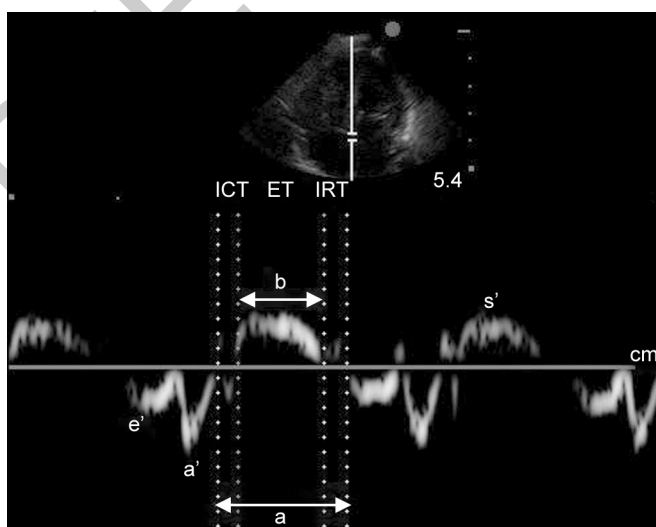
Various parameters of tissue Doppler. (a': atrial systolic velocity; e': early diastolic velocity; ET: ejection time; ICT: isovolumetric contraction time; IRT: isovolumetric relaxation time; MPI: myocardial performance index ($a-b/b$); S': peak systolic velocity)
